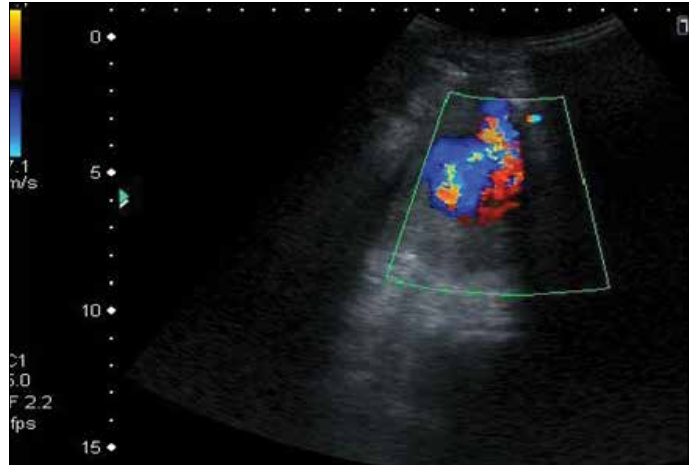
Color Doppler USG image showing characteristic "ying-yang" appearance in the pseudoaneurysmal sac
